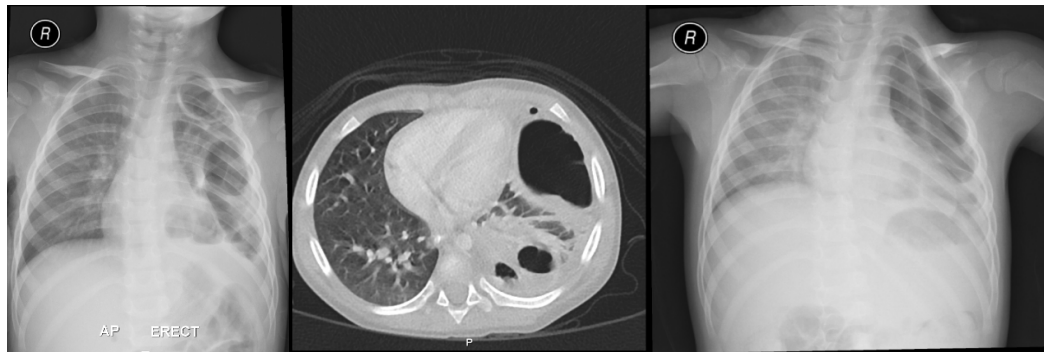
12 months- old patient presented with severe cough and fever. A) X ray shows opaque left hemithorax. B) CT shows bilateral pneumonia and left pleural effusion C) Follow up shows partial resolution of the left sided opacity
